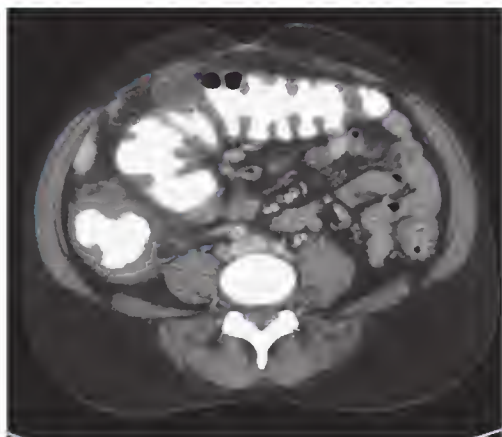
Computed tomography scan of a patient with lupus enteritis demonstrating bowel wall edema involving the entire small and large intestines, or pancolitis.
